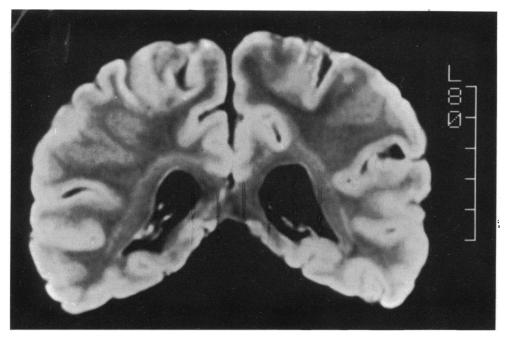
A coronal MRI slice through the forebrain showing the lateral ventricles. The scale to the right represents an actual length of 5 cm.
